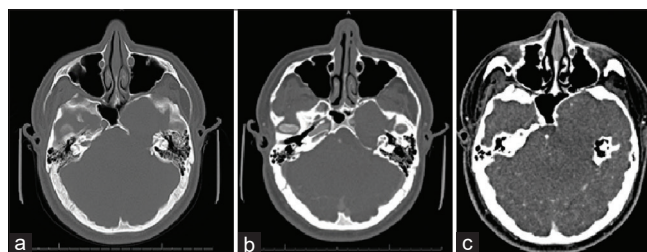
Diagnostic computed tomography angiogram figure description: bony erosion and remodeling of the left sphenoid and petrous temporal bones are seen, related to the mass (a and b). On contrasted imaging (c), angiography demonstrates external compression (approximately 50% narrowing) of the cavernous and petrous segment of the left internal carotid artery.
